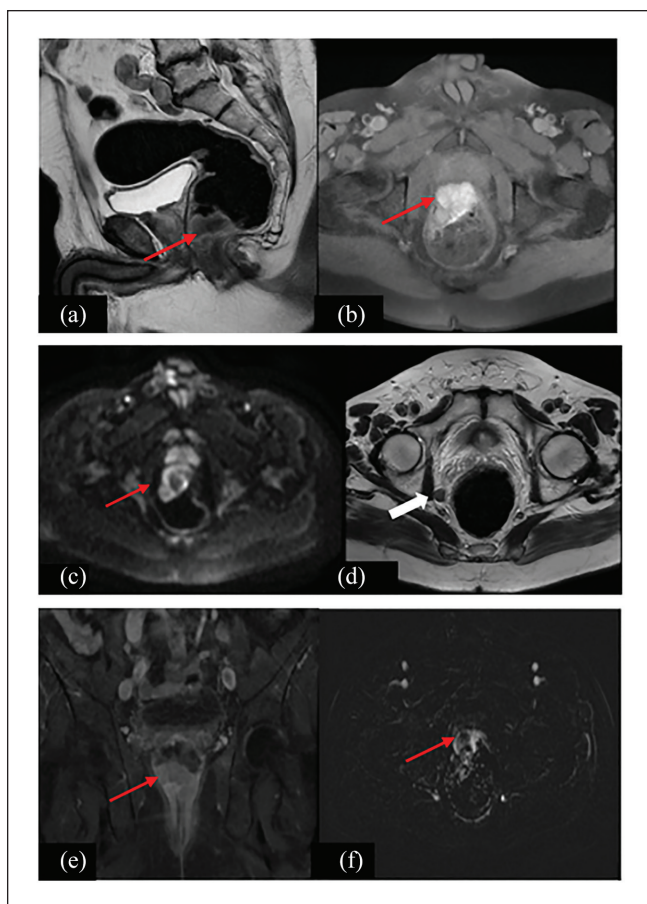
MRI of the pelvis of the same patient demonstrates an intermediate signal lobulated rectal mass on sagittal T2w images (a) (red arrow), T1 hyperintense (b), restrictive in diffusion sequences (c), and strongly enhancing in post-enhanced and subtracted images (e, f). This mass extends to anal sphincters but respects the peri-rectal fat. Mesorectal lymphadenopathy is also found (f) (white arrow).
